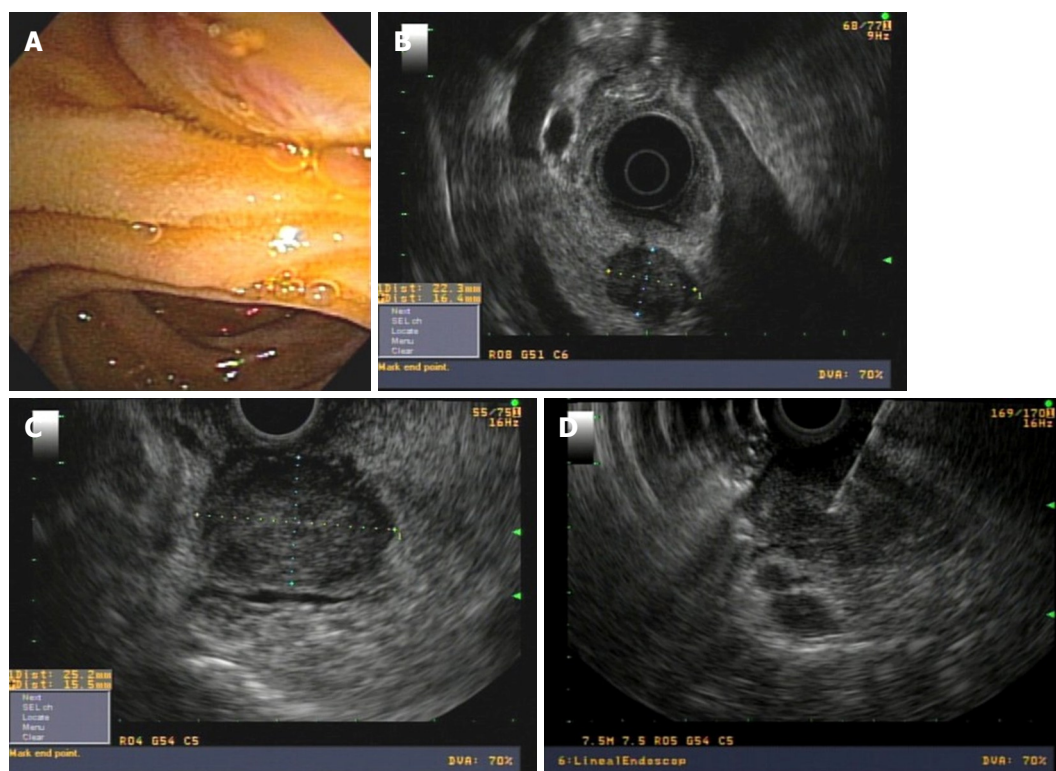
Periampullary tumor. A: Normal papilla in endoscopic view; B: Radial endoscopic ultrasound (EUS) finding of periampullary tumor; C: Linear EUS view; D: Fine needle aspiration puncture.
